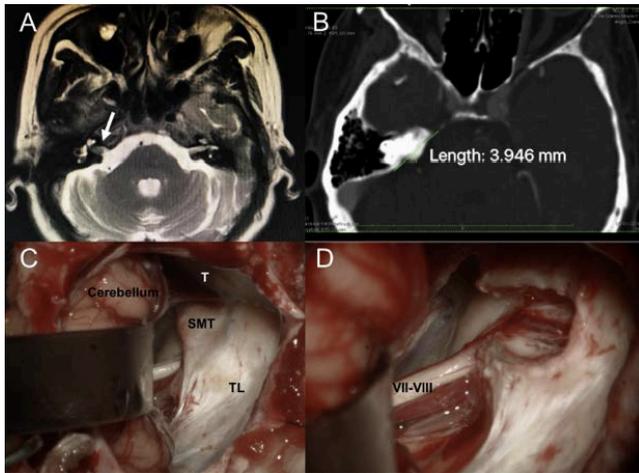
Clinical case 1: A. Preoperative MRI in a T2 sequence shows that an intracanalicular tumor occupies the right IAC signaled with a white arrow. B. A preoperative CT scan reveals an enlarged posterior SMT type III, which is measured. C. After a right retrosigmoid approach showing the CPA, the SMT is found intraoperatively enlarged, and its drilling was required. D. After the drilling is completed, the tumor was removed, allowing safe preservation of the facial nerve. T: tentorium; TL: Tübingen line, SMT: Suprameatal tubercle, VII-VIII: Seventh and Eighth cranial nerves.
